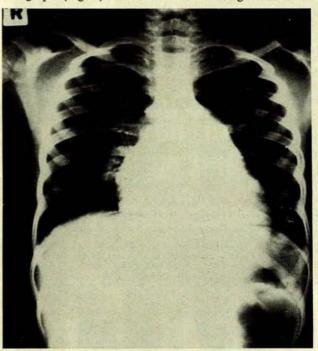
Anteroposterior chest radiograph of case 1.
